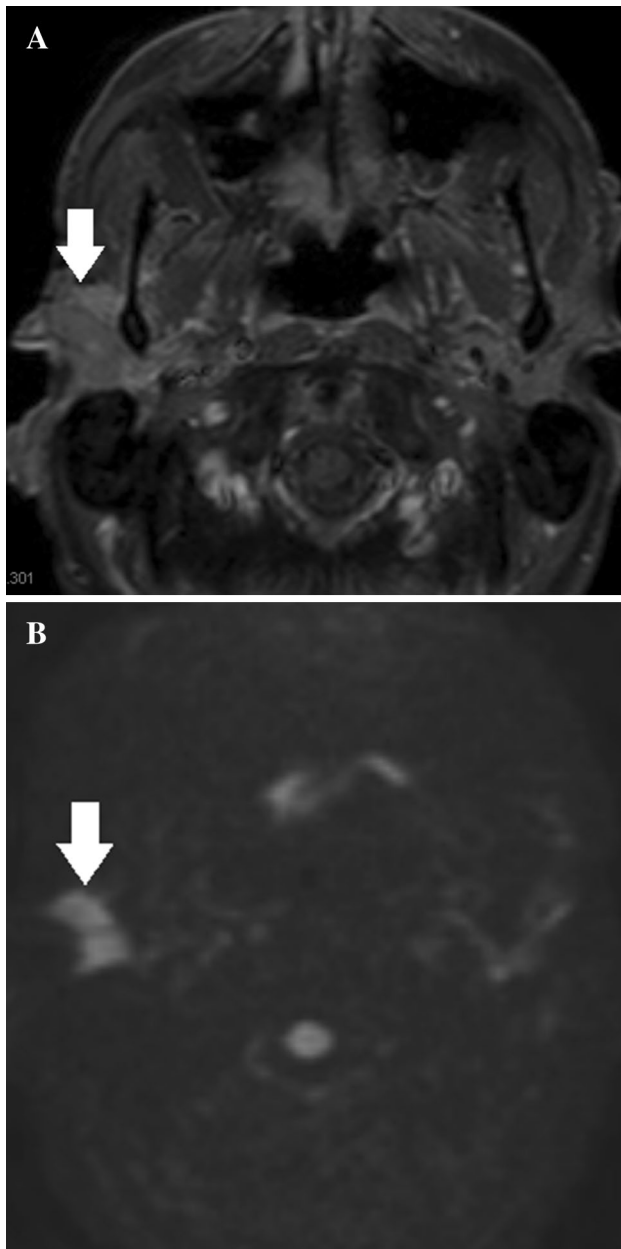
(a) Postgadolinium T1-weighted image a from a 38-year-old male with previous parotid adenosquamous carcinoma shows an enhancing lesion involving the parotid bed (*arrow*). (b) DWI with $b = 1,000$ shows increased diffusion signal (*arrow*) and corresponding low ADC (*not shown*), which is suggestive of malignancy. This was a biopsy-proved recurrent parotid carcinoma
